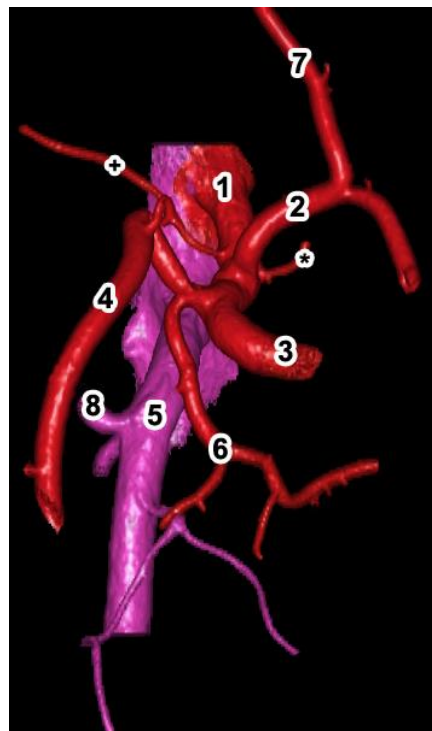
Both inferior phrenic arteries arise from the celiac trunk, the GDA is also a direct branch of the celiac trunk. 3D CT reconstruction.
